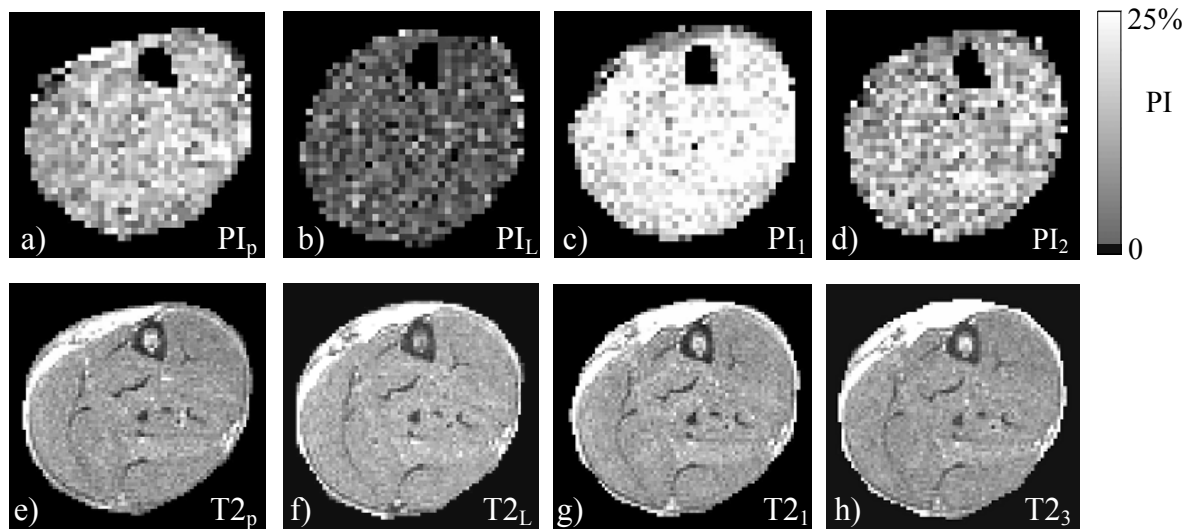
Perfusion index (PI) maps (a-d) and T2-weighted-sum images (e-h) of lower limb for a typical tourniquet-experiment. Top row shows PI maps a) before and b) during application of tourniquet and c) 5 minutes and d) 90 minutes after deflation of tourniquet. Bottom row shows T2ws images measured e) before and f) during tourniquet and g) 40 and h) 115 min after deflation of tourniquet.*
